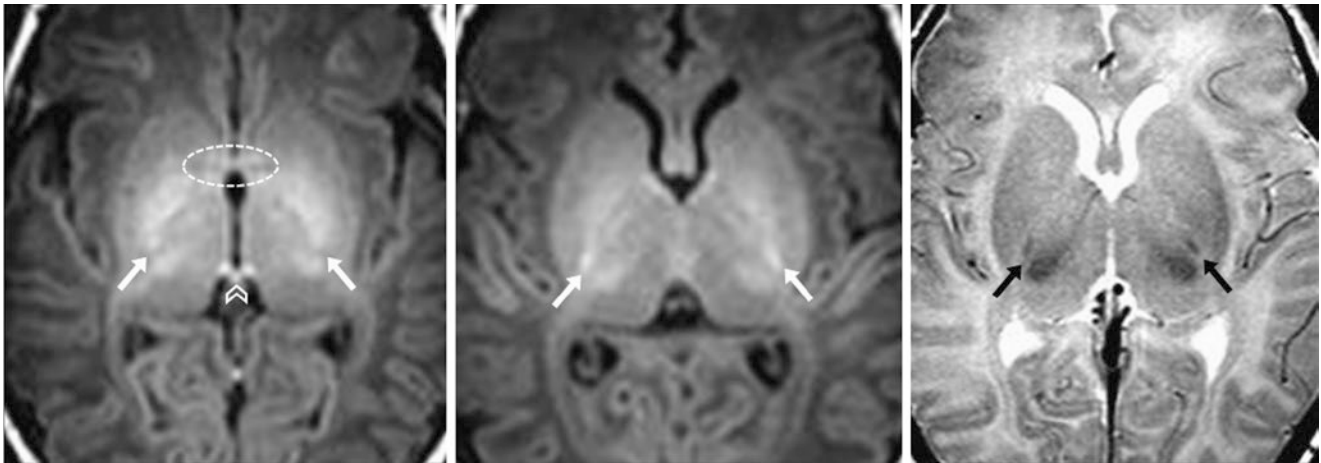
A 5-day-old term neonate had a normal 3T MRI with GE T1WIs (*left* and *middle*) and SE T2WI (*right*). The habenular commissure (HC) (*chevron*) and posterior limbs of the internal capsules (PLIC)
